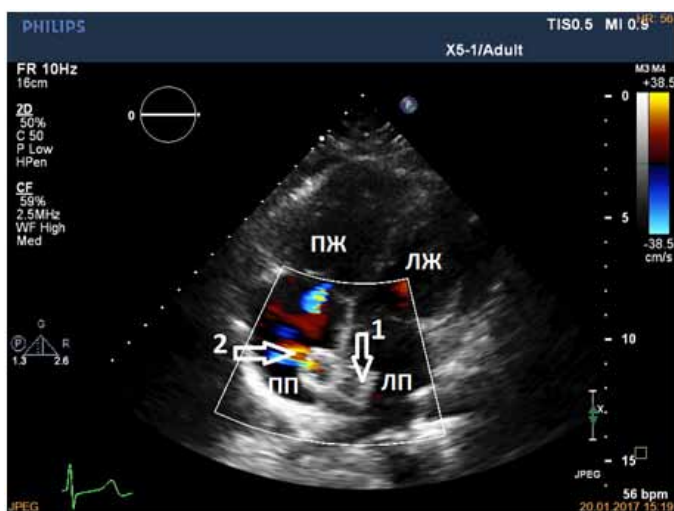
Modified apical 4-chamber view with color Doppler demonstrating L→R flow across the stent in the interatrial fenestration. 1 – butterfly stent, 2 – note the left-to-right shunt through the stent.
